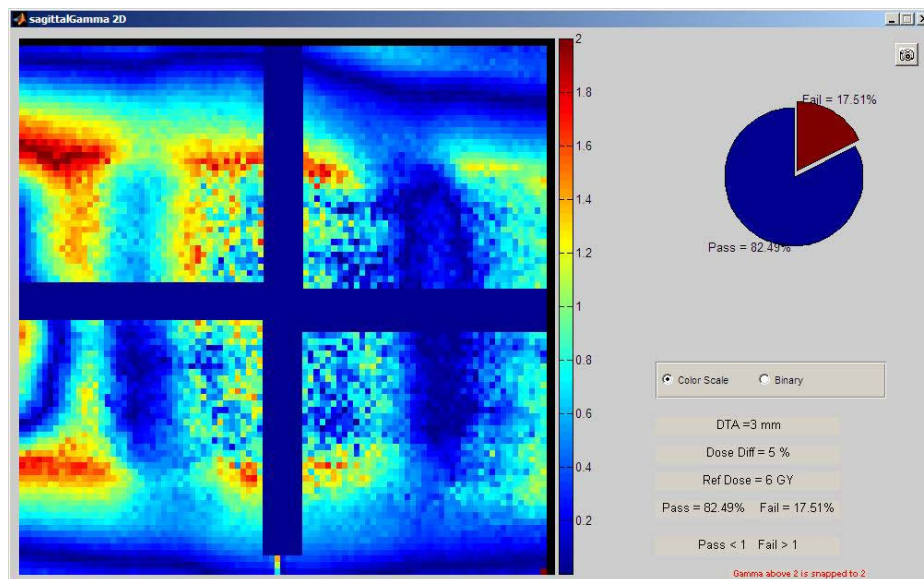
Plan 1b Trial 2 Sagittal Gamma Analysis with PVC Shell contoured and CT Number set to match Eclipse Calibration Curve
